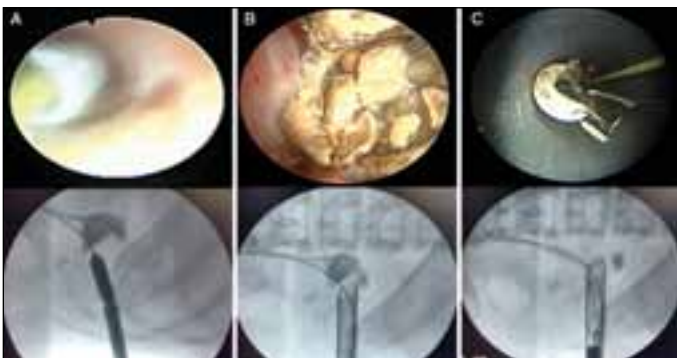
A – Endoscopic monitoring of tract dilation and sheath advancement is performed to prevent underdilation into renal parenchyma or overdilation leading to collecting system perforation; B - For stone fragmentation, the ultrasonic is used through the rigid nephroscope; C - Stone fragments are actively retrieved with a permanent 3-prong grasper or disposable basket and the stent is removed from above.
